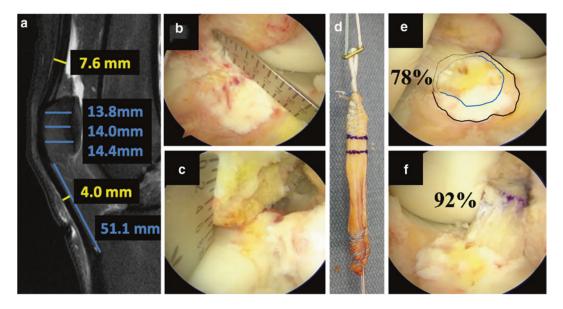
Example of individualized anatomic ACLR case. a Preoperative measurement of potential autograft dimensions on MRI and ultrasound (not shown). Confirmation of b tibial and c femoral insertion sites with arthroscopic ruler. d Given this patient's sizing of possible grafts, native ACL dimensions, and sporting activity, a soft-tissue quadriceps tendon autograft was most appropriate. The graft restored e 78% of the native tibial insertion site area and f 92% of the native femoral insertion site area. Black lines outline native tibial footprint; blue lines outline graft footprint within native footprint
